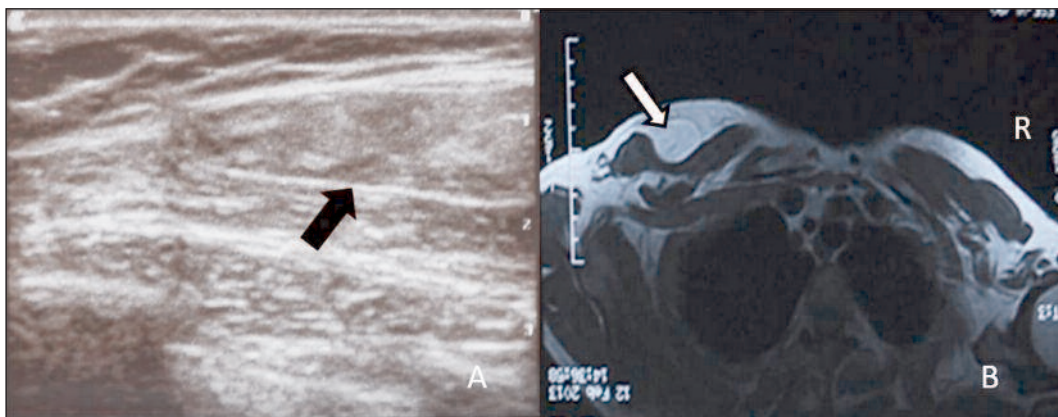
A) Ultrasonographic images of the lipoma occurring within pectoralis major muscle. B) Magnetic resonance imaging of homogenously hyperintens lesion in front of the pectoralis major muscle.
